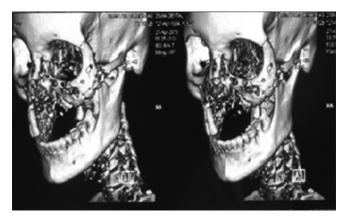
Three-dimensional reconstruction of computed tomography showing bone destruction and erosion of the left maxilla with antral involvement
